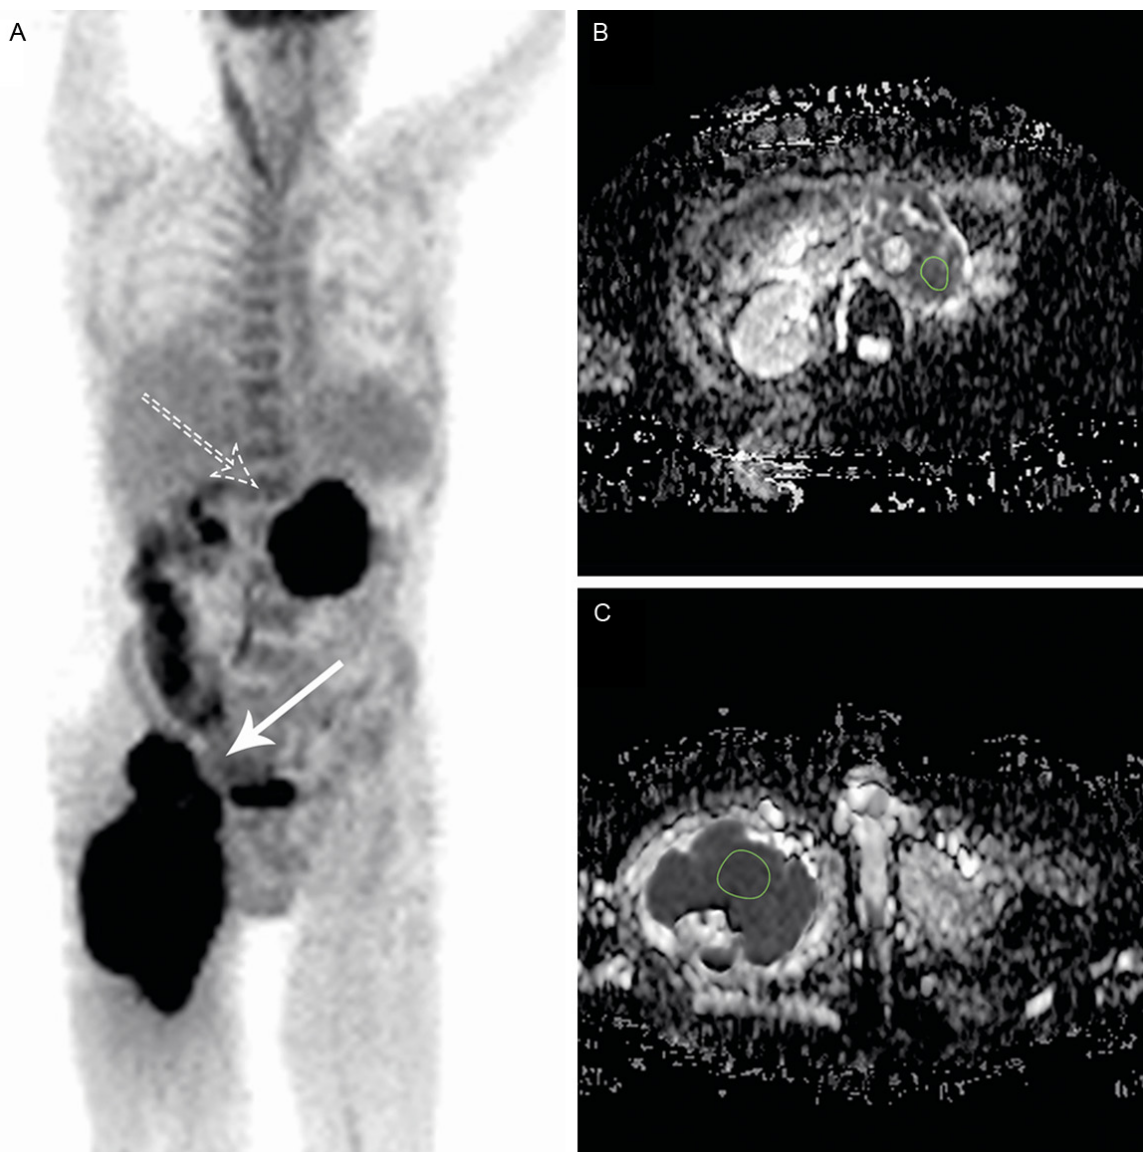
Coronal FDG-PET (A), axial ADC map at the para-aortic region (B), and axial ADC map at the inguinal region (C) in a 74-year-old man with newly diagnosed DLBCL. These images show lymphomatous involvement of confluent para-aortic lymph nodes (dashed arrow) and a large tumor mass in the right inguinal region extending into the right quadriceps femoris muscle (continuous arrow). The axial ADC maps show the single slice, transversal, manually drawn region of interest (ROI). SUV_{max} , SUV_{mean} , and SUV_{peak} were measured in both the lesion with the visually highest FDG uptake and in the largest lesion. ADC_{mean} was measured in the same lesions. SUVs were based on body weight and measurements were executed using the Siemens Syngo workstation (version VA11A), whereas ADC measurements were made using OsiriX DICOM Viewer (version 5.5.1). In this case, SUV_{max} of the most FDG avid (para-aortic) and the largest (inguinal) lesion were 18.5 and 24.3, respectively. ADC_{mean} of the most FDG avid and largest lesion was $0.61 \times 10^{-3} \text{ mm}^2/\text{s}$ and $0.43 \times 10^{-3} \text{ mm}^2/\text{s}$, respectively.
